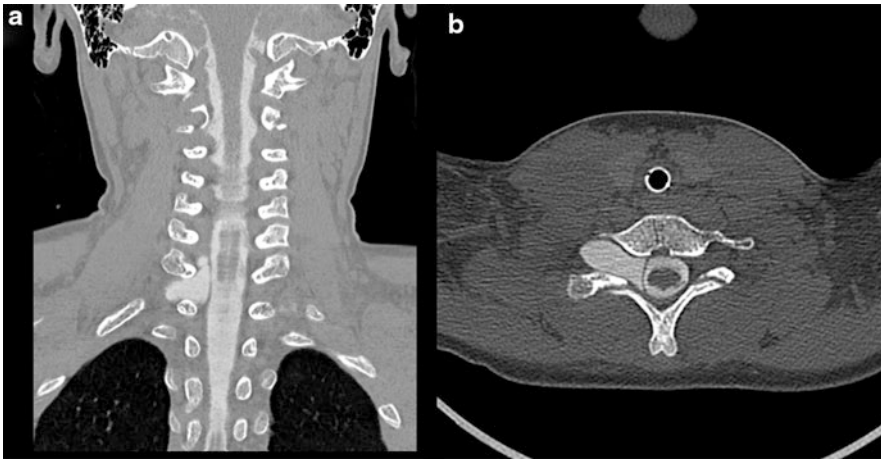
MRI of patient with pseudomeningoceles at right C6, C7, and T1 levels. (a) Two right-sided cervical pseudomeningoceles are seen on coronal view; (b) axial
